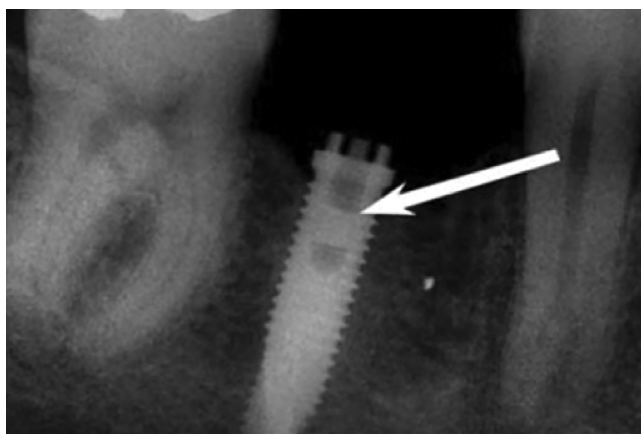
Radiograph used to confirm remaining screw fragment.
